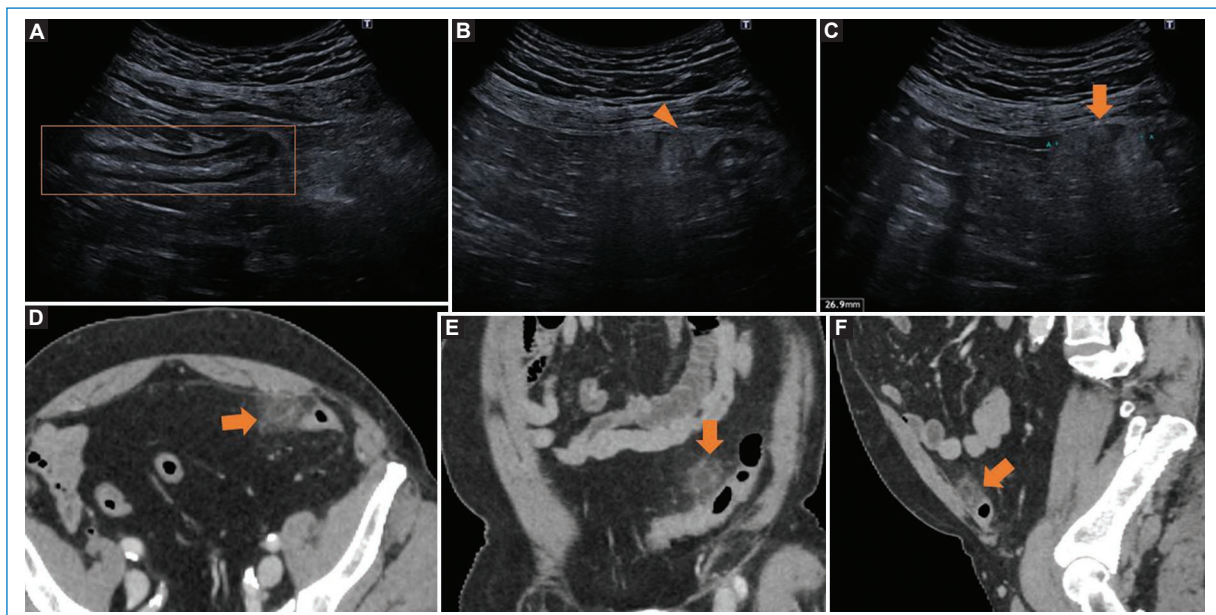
A 72-year-old male who presents to the emergency department for pain in the left iliac fossa. He has neither fever, nor nausea nor vomiting. As personal history he has hypertension, type 2 diabetes, obesity and dyslipidemia. A: ultrasound where descending colon without diverticula is observed. B and C: ultrasound in which focal hyperechogenicity of the fat adjacent to the colon is identified (arrows). D: Axial oblique CT. E: Coronal oblique CT. F: Sagittal oblique CT. Focal inflammatory changes of the fat adjacent to the colon are identified, round in morphology, with a peripheral hyperdense ring-shaped image and a central linear image (visible in reconstruction D), compatible with the thrombosed vein, all in relation to epiploic appendagitis in the sigmoid (arrows). CT: computed tomography.
